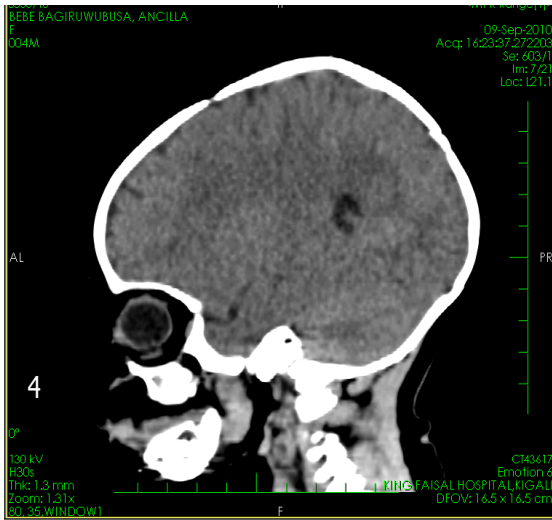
Brain CT-scan and orbits. The orbits appear in the orbital sockets but there is no lens visualised in the left orbit.
